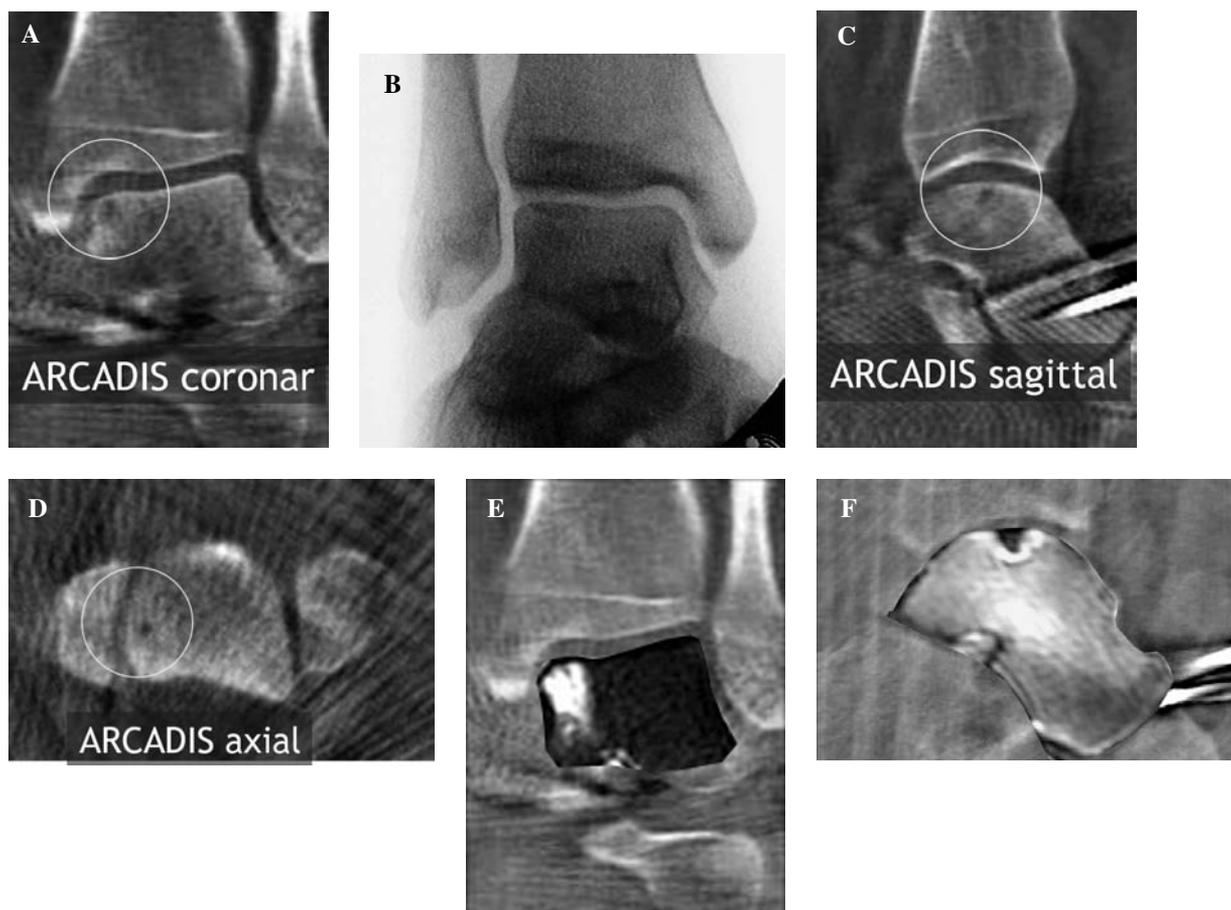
Intraoperative image acquisition with ARCADIS. A, A 2D-image without sufficient visibility of the OCD lesion. B to D, The reformations of the 3D dataset from the ARCADIS scan with good visibility of the OCD lesion. E and F, An optional image fusion of the MRI image and the ARCADIS 3D-reformation for better visualization (E, Fusion of coronal MRI T2 image of the talar body with a coronal ARCADIS 3D reformation; F, Fusion of parasagittal MRI T1 image of the talar body with a parasagittal ARCADIS 3D reformation).
